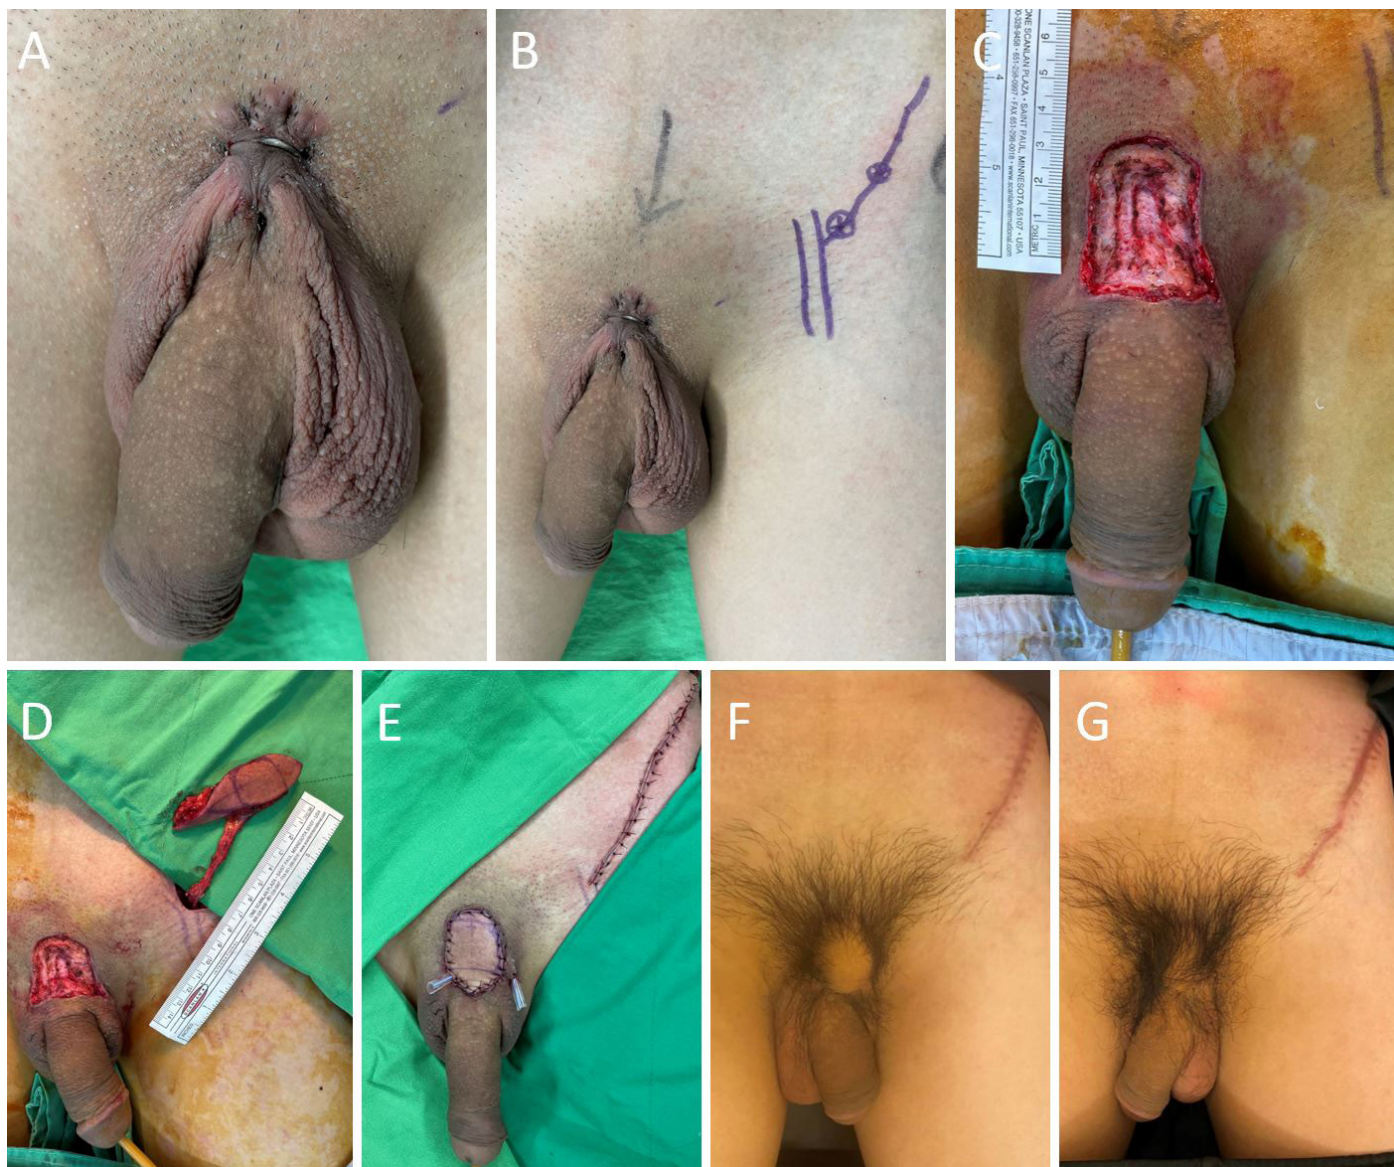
A 27-year-old male with a severe scar contracture at the penopubic junction. (A) Due to the scar contracture at the penopubic junction, there is a short penis and a high hanging scrotum. (B) A handheld doppler is used to determine the direction of the superficial branch of the superficial circumflex iliac artery. This branch travels beyond the anterior superior iliac spine in an axial pattern. (C) Following the excision of the contracture scar, there is a defect measuring 4 x 3 cm. (D) The length of the pedicle is 7 cm. (E) The flap is transpositioned through a subcutaneous tunnel and then tailored to fit the defect. At the donor site, a primary wound closure is performed. (F) One month after surgery, the patient recovers uneventfully. (G) The flap with hair growth is viable and durable three months after surgery.
